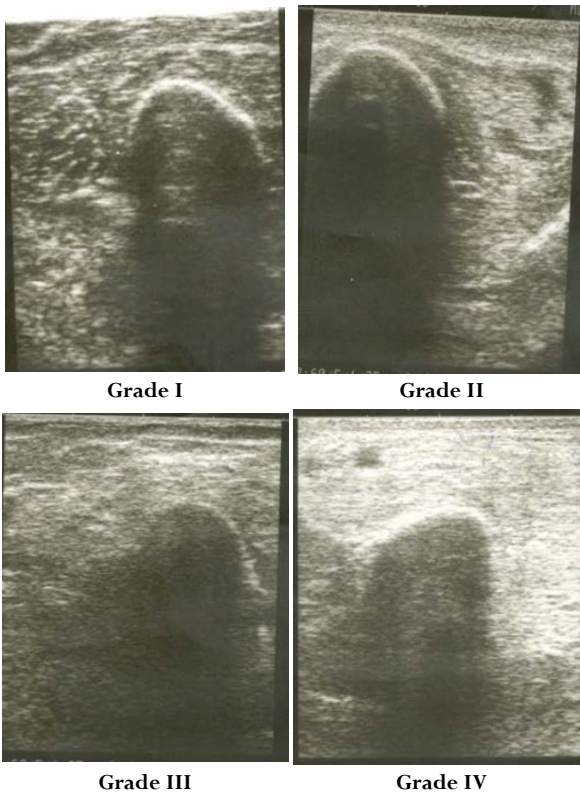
Ultrasound of biceps brachii muscle showing different grades in echogenicity as defined by the Heckmatt score
